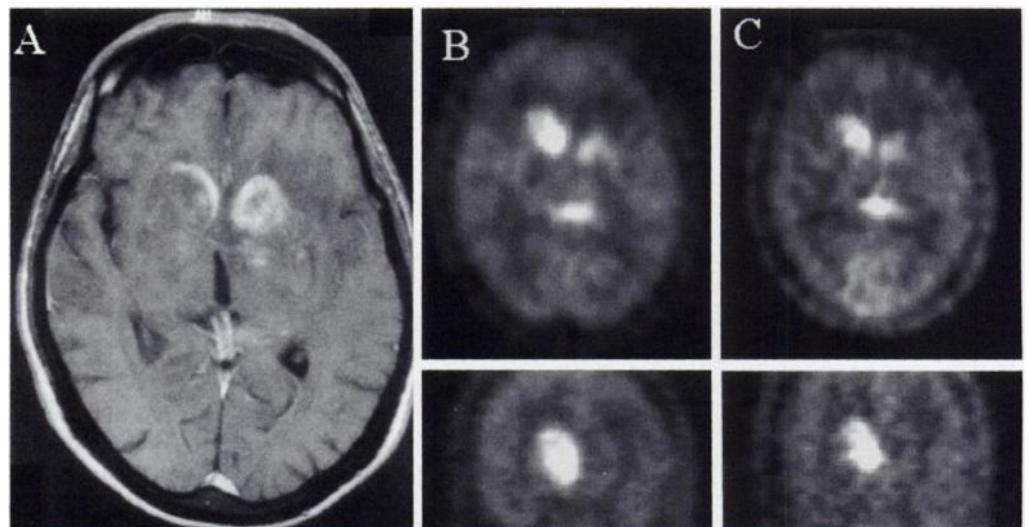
MR appearances in a patient with cerebral lymphoma (A), demonstrating the high-grade uptake of both FDG (B) and MET (C) within the lesions, shown in transaxial and coronal slices.
